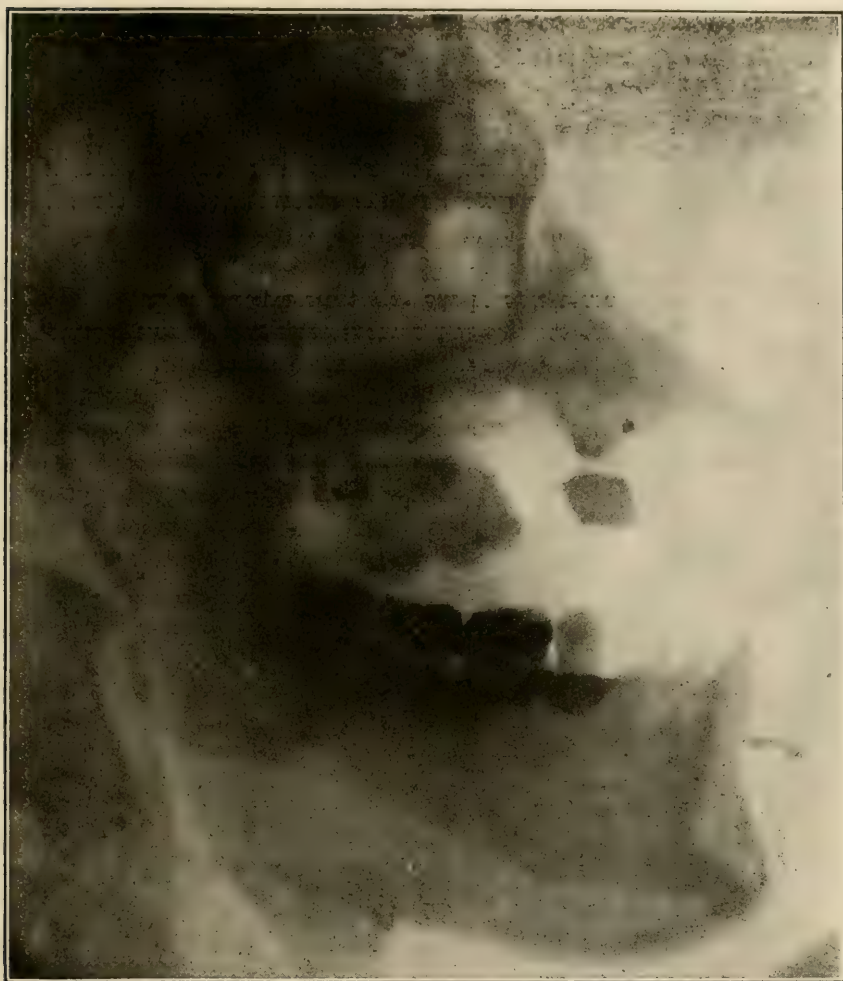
Same case as Fig. 277 after removal of the piece of tooth root. (Radiograph by Carman, of St. Louis.)
